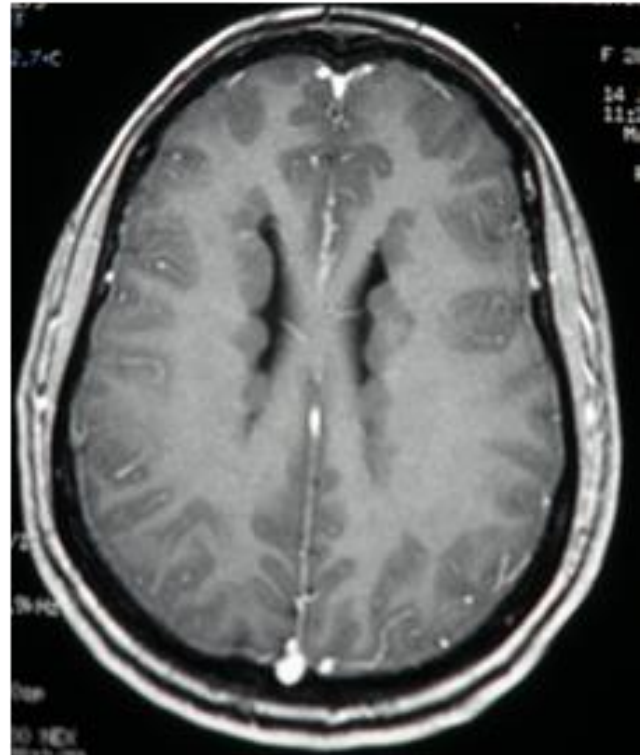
T1 and T2 MRI images of the 28 year old mother showing periventricular nodules isointense to cortical gray matter on MRI, that did not enhance with gadolinium
